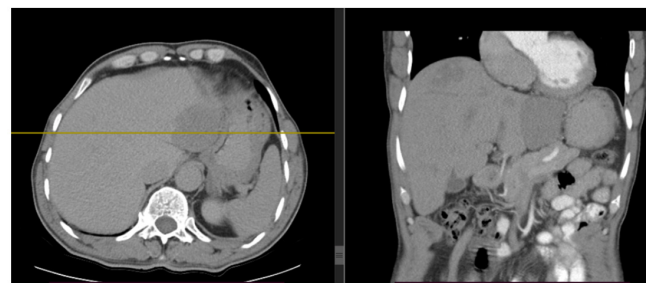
Left image: Native CT. Right image: Post-contrast CT.
